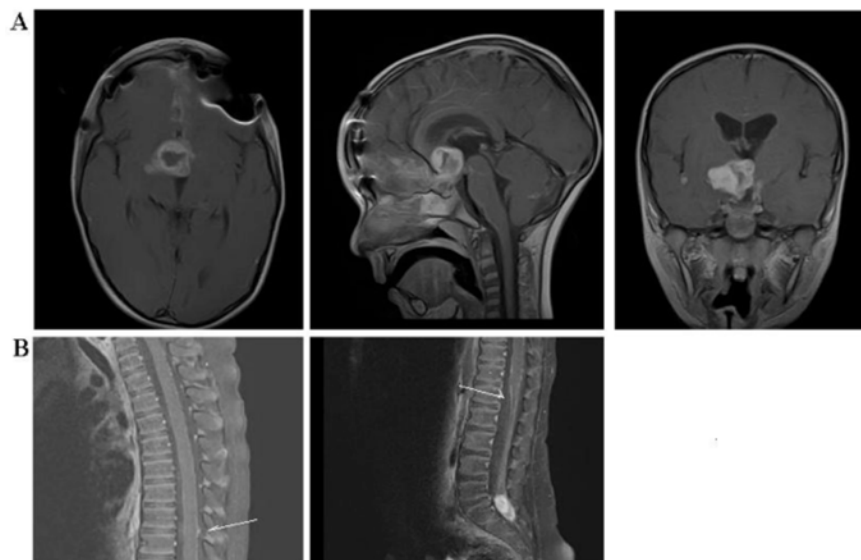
Pilocytic astrocytoma of the optic chiasm disseminated leptomeningeally into the spine. A) Cranial magnetic resonance image shows the pilocytic astrocytoma growing from the optic chiasm and invading the hypothalamus and the third ventricle; B) Leptomeningeal contrast enhanced areas in the spine with a node around the nerve roots S1 and S2.
